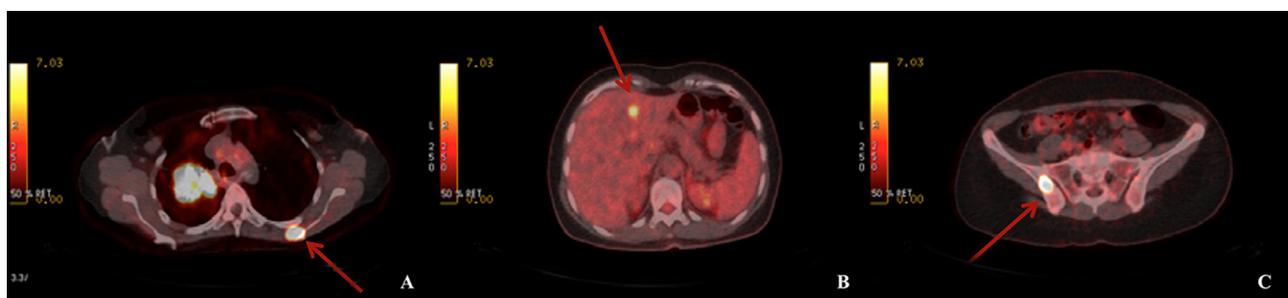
Typical case of NSCLC upstaging using ^{18}F -FDG PET/CT. Note: A) Primary lesion in the right lung and metastatic lesion in the scapula, B) metastatic lesion in the liver and C) metastatic lesion in the right ilium (sacroiliac joint).
